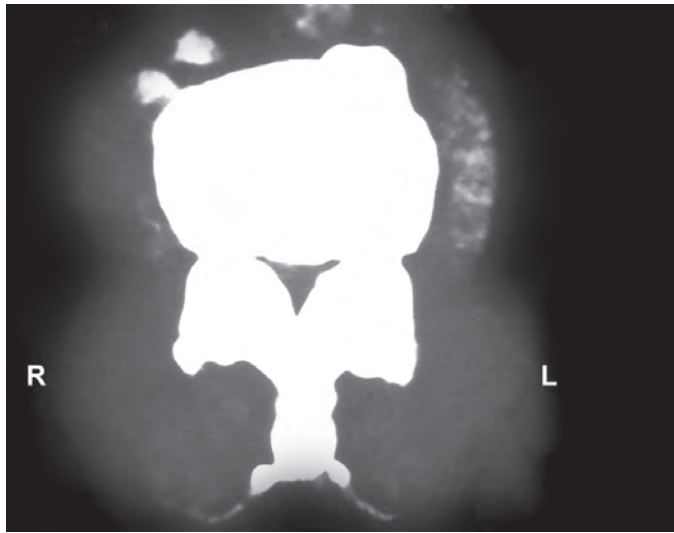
Axial CT scan of dorsal vertebra in fluorosis showing severe compression of the cord
